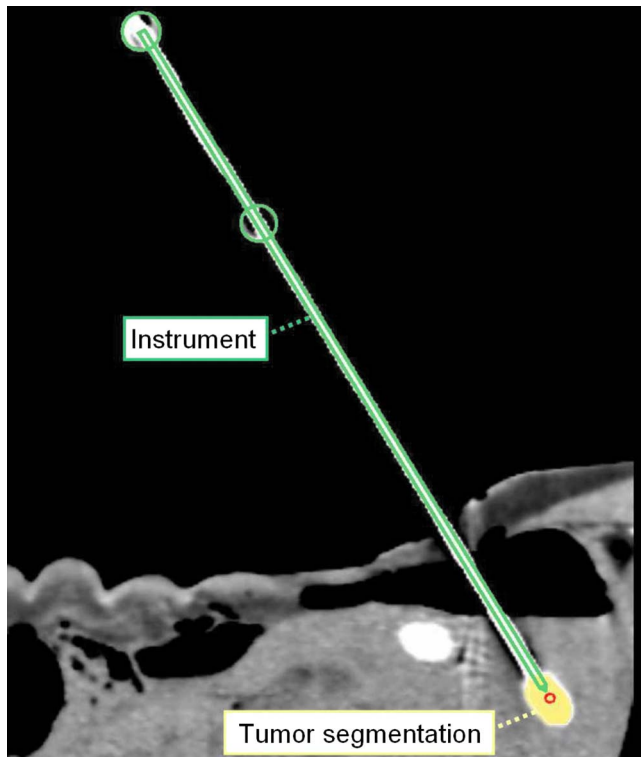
Control CT scan showing the registered instrument, the segmented lesion within the liver, and the center of gravity of the lesion.
